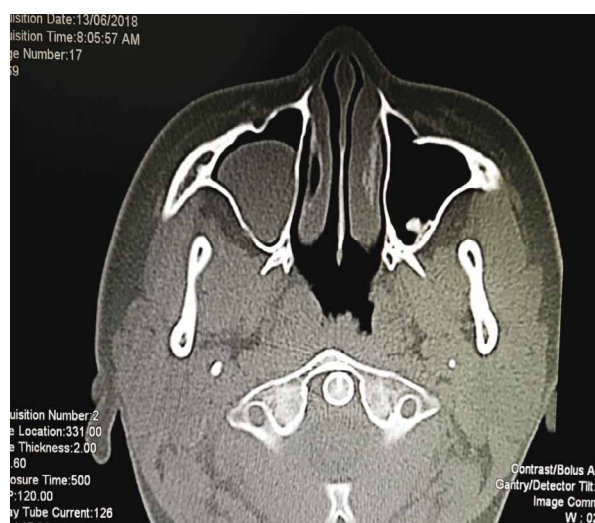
Computed tomography of the paranasal sinus revealed a soft tissue mass within the maxillary sinus
